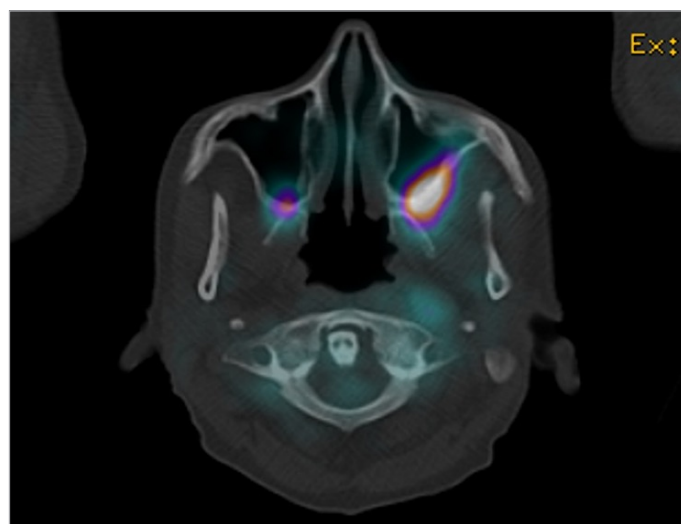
Bone involvement by PET-CT in Erdheim-Chester disease.
